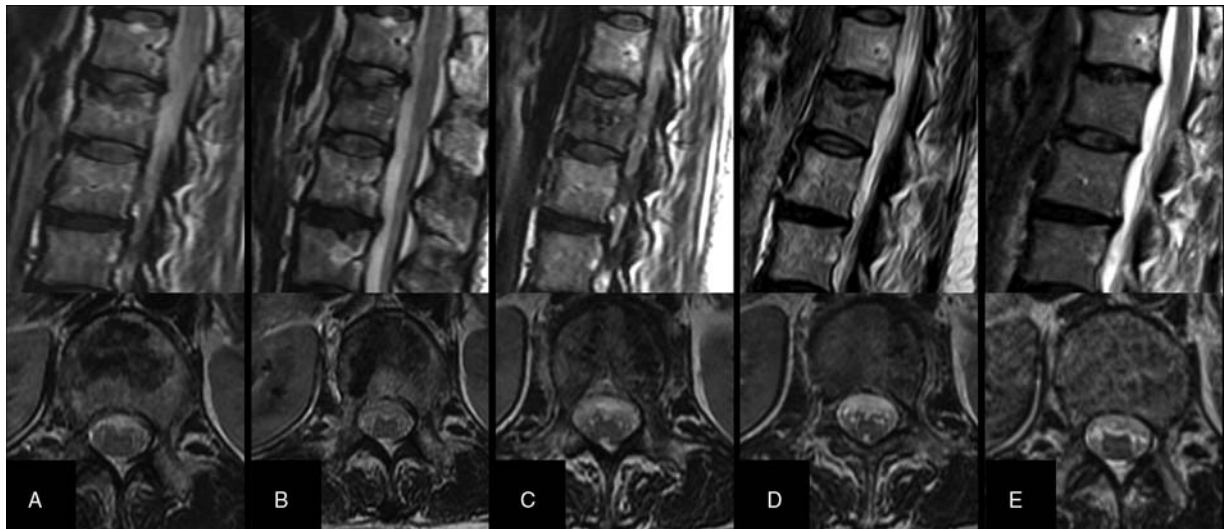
MRI images of thoracolumbar segment. (A) Preoperative sagittal and axial images revealed that L1 vertebral height was lost, signal was decreased, and no abnormal signal was found in the spinal cord. (B) MRI images of 1 d after operation, (C) MRI images of 30 d postoperative, (D), MRI images of 60 d after operation, and (E) MRI images of 180 d after operation. MRI = magnetic resonance imaging.
